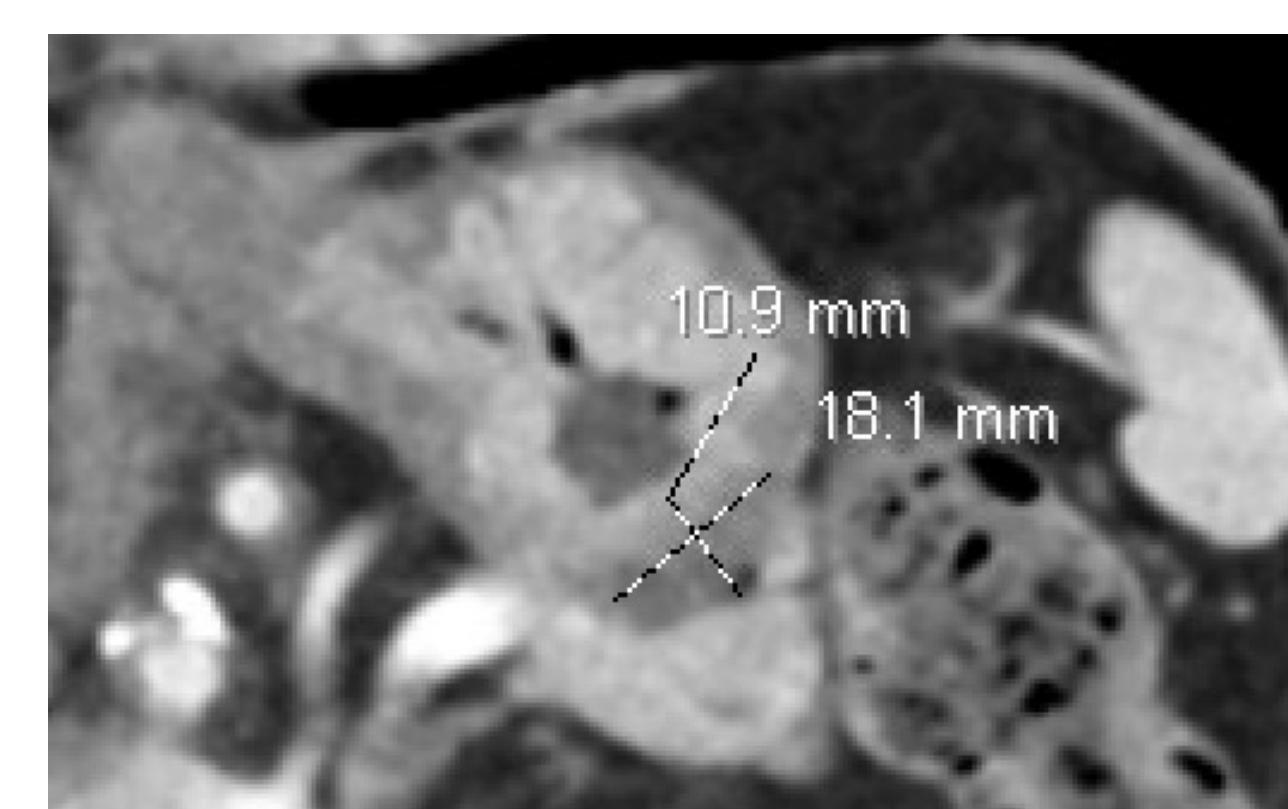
Intramural lesion within greater curvature at level of gastric fundus measuring 1.8 x 1.3 x 1.1 centimeter on CT scan. Abbreviations: *CT* (computed tomography)
